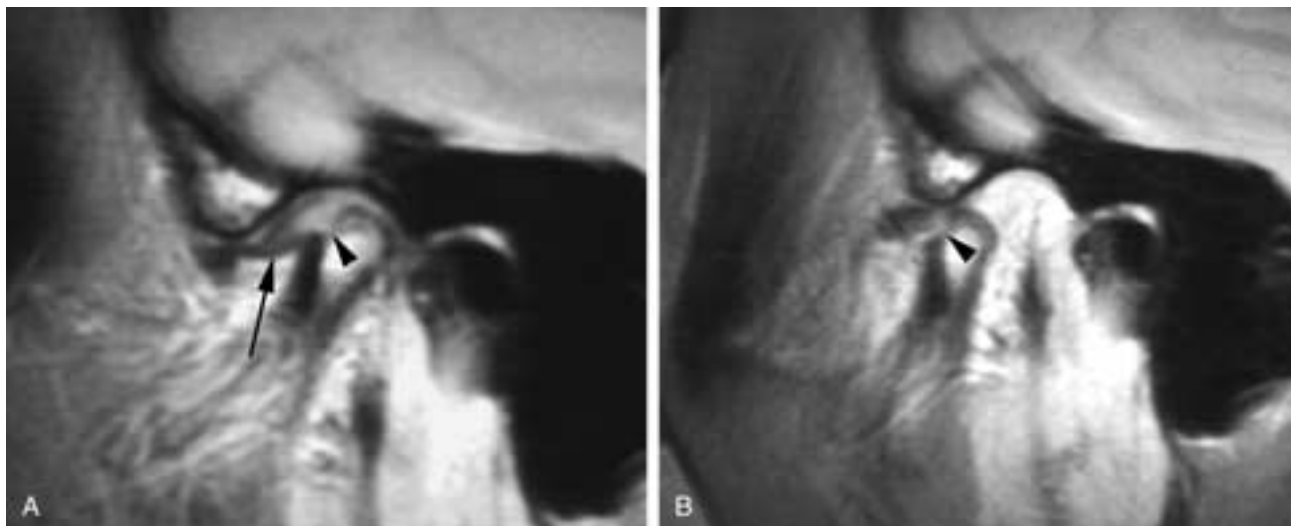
Osteoarthritis with erosion of the condylar head. A, Proton density MR image shows a defect (arrowhead) in the head of the condyle. The disk is completely dislocated anteriorly, with the posterior thick band (arrow) completely anterior to the condylar head. B, Open-mouth position. The condyle pushes the disk anteriorly but does not recapture. Note how the posterior thick band fits into the cortical defect (arrowhead) and the head of the condyle.
